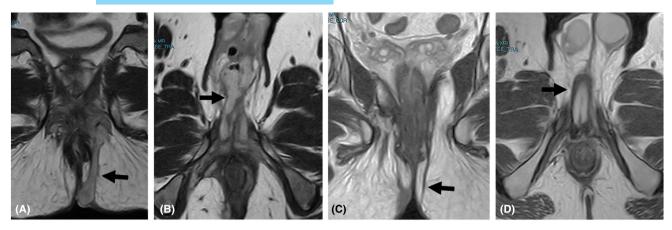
Complete radiological healing on 3 months postoperative MRI after SVF combined with PRP treatment in one patient with treatment-refractory pCD with a high transsphincteric fistula. (A, B) Preoperative MRI (coronal (A) and axial (B)) view showing a high transsphincteric fistula with perineal extensions (arrows). (C, D) postoperative MRI (coronal (C) and axial (D)) showing complete radiological healing with no residual fistula tracts.
